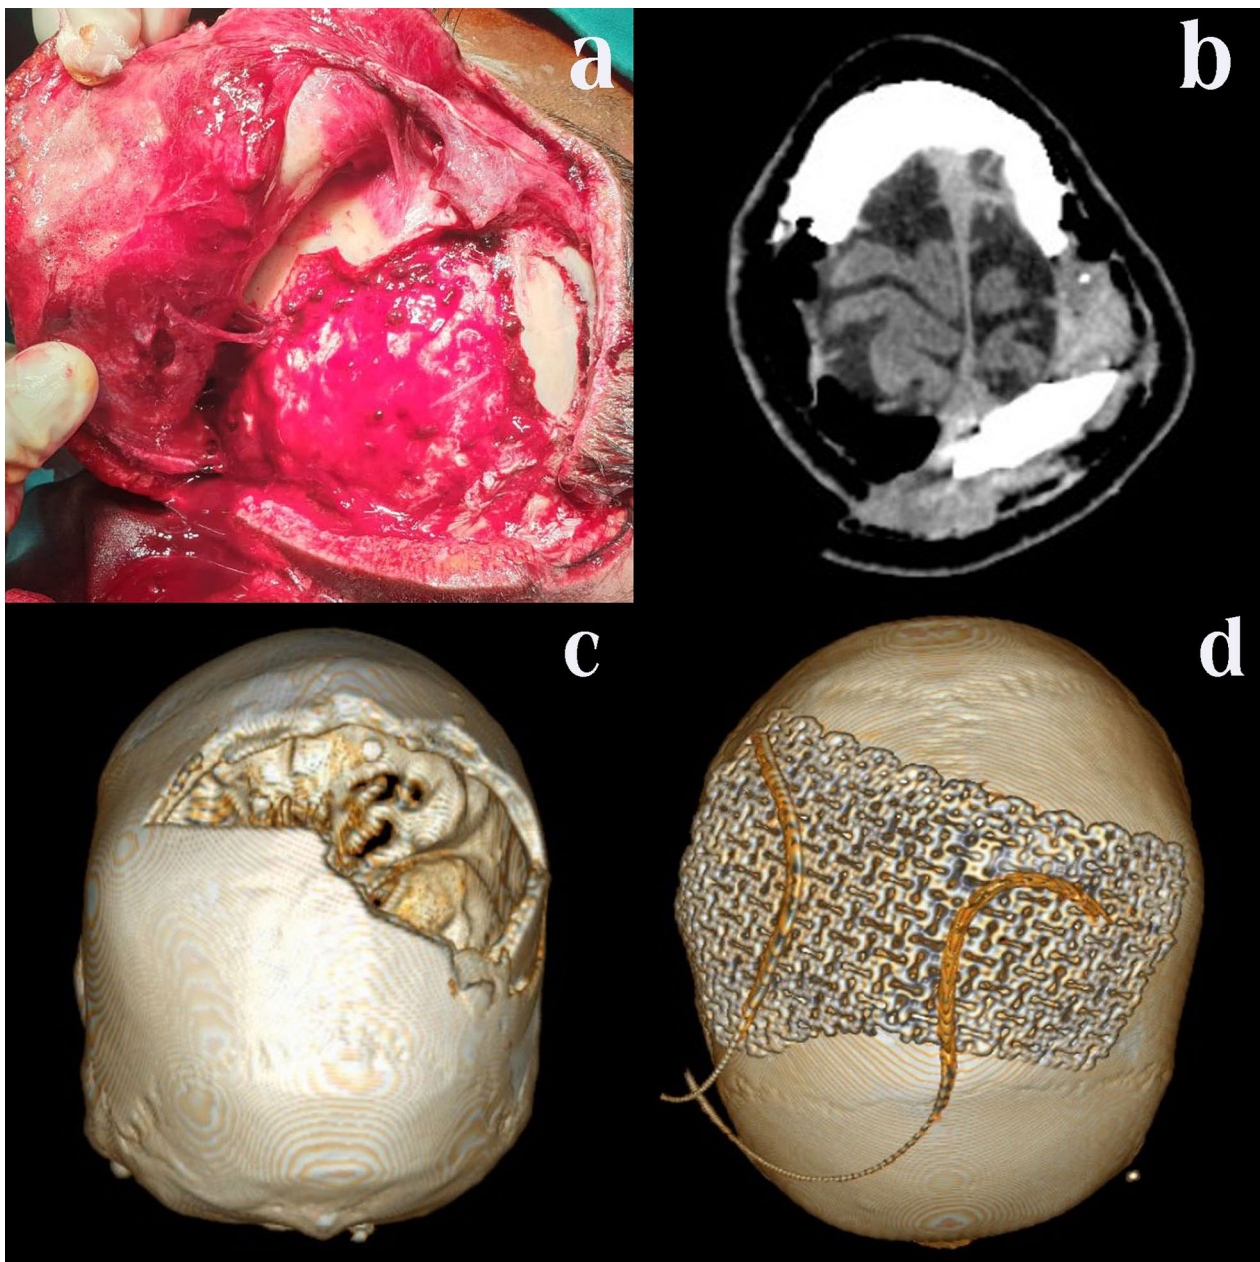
a The open wound of scalp with bleeding, and large skull defect; b CT head showing skull defect, and extradural bleeding from midline to left side; c 3D CT showing the large defect; d 3D CT after cranioplasty with titanium mesh
